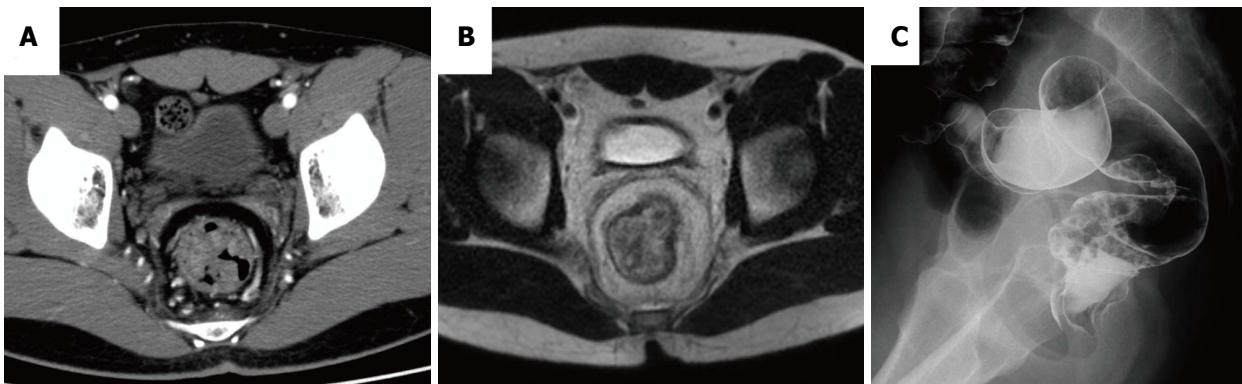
Multiple elevated lesions with wall thickening in the sigmoid colon. Rectum on computed tomography (A) and magnetic resonance imaging (B); Barium enema shows a collection of small sessile polyps in the sigmoid colon and rectum (C).
